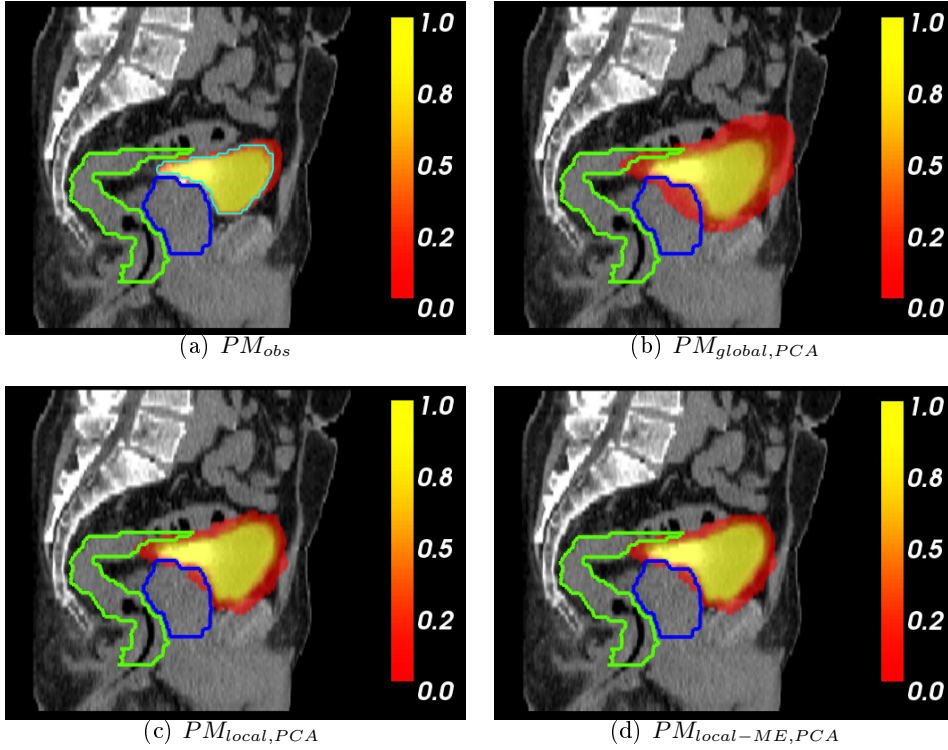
3D sagittal views of PMs obtained for one patient in the validation database as an out-of-sample patient. Segmented prostate (blue) and rectum (green) at the planning CT scan are overlaid. Top left figure also depicts the segmented bladder (cyan) at the planning CT.
